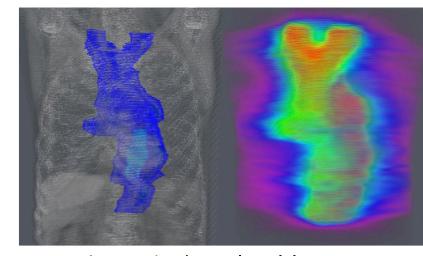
CT plan and total dose map
